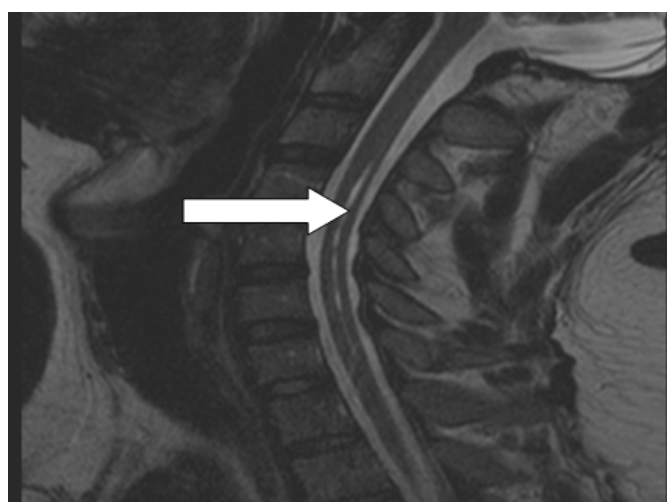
Postoperative cervical MR image. Sagittal T2 MR image of the patient's cervicothoracic region with markedly decreased syrinx.
